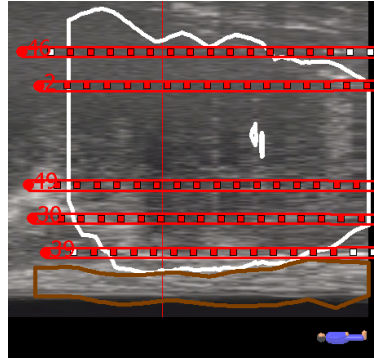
Sagittal transrectal ultrasound scan with the PTV delineated in white. The red dwell positions are included in the original dataset, the white ones are added to obtain the extended set of dwell positions.
